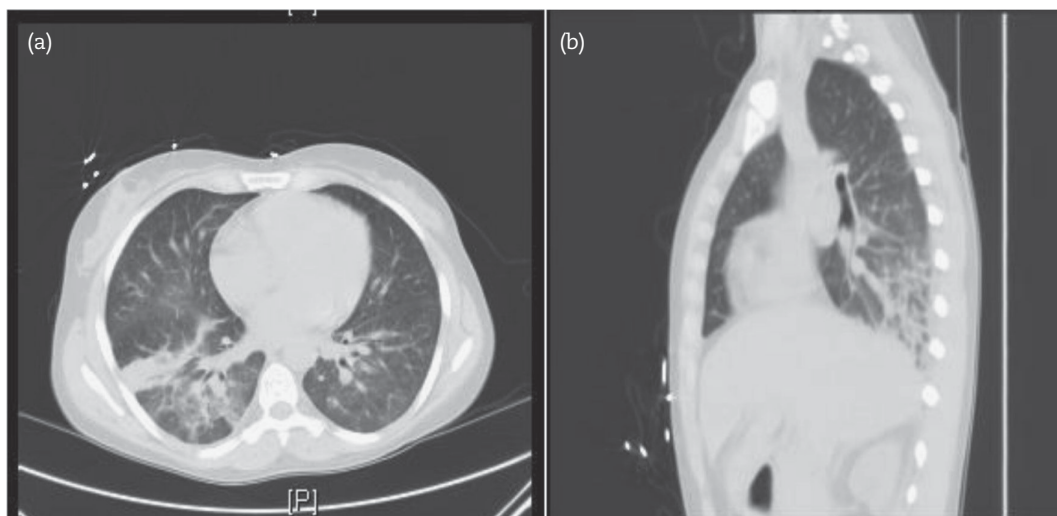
CT chest showing interstitial edema and right greater than left lower lobe consolidation likely from CMV and EBV. 1a transverse view 1b. sagittal view.
